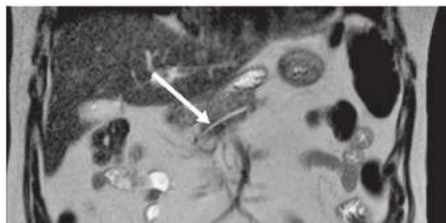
• A coronal MRI scan shows a 2-cm insulinoma in close proximity to the main pancreatic duct in the head of the pancreas (*white arrow*). After confirmation of the duct by intraoperative ultrasound, a pylorus-preserving pancreaticoduodenectomy was performed.
